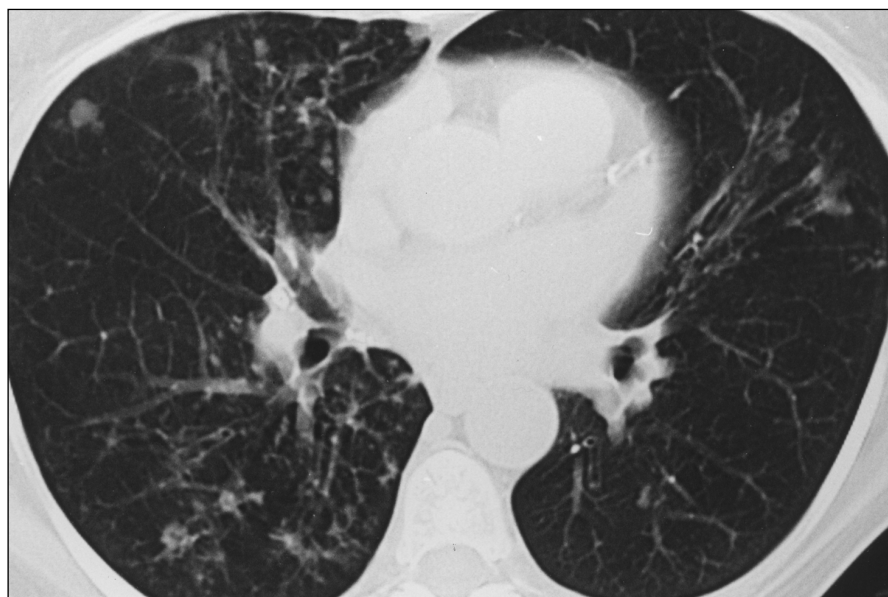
61-year-old woman with pulmonary *Mycobacterium chelonae* infection. Helical CT scan through lower lungs shows pulmonary nodules and cylindric bronchiectasis in lingula.
